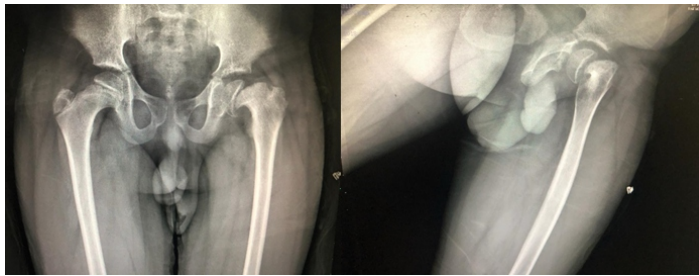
(a and b) Anteroposterior and lateral plain radiograph of pelvis with both hips showing a left hip SCFE with open proximal femoral physis and bone age of risser stage 0 and open triradiate cartilage.
